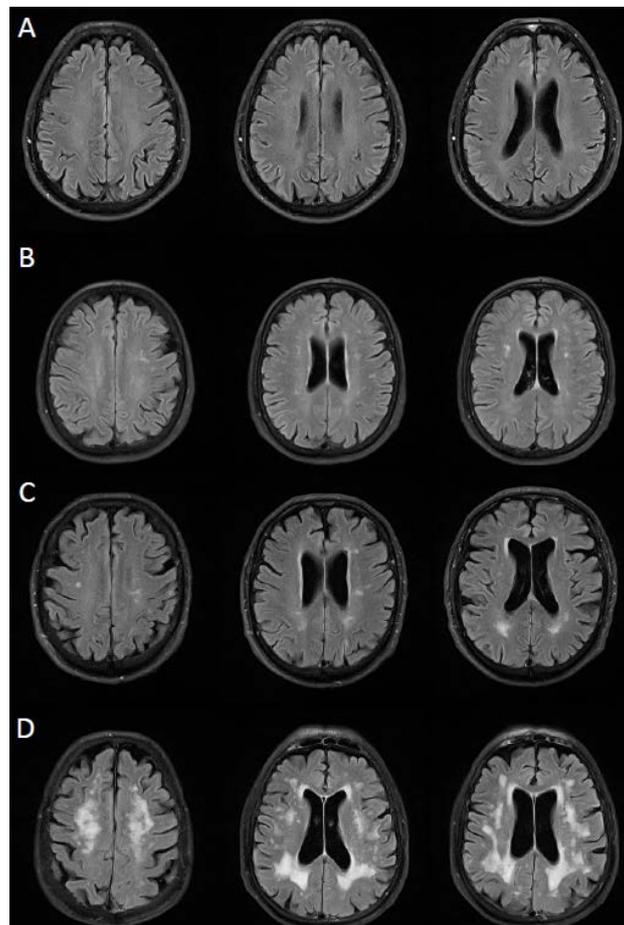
A fluid-attenuated inversion recovery (FLAIR) magnetic resonance imaging (MRI) sequence of a 66-year-old male patient (A) with an overall Fazekas and Wahlund score of 0. A 70-year-old female patient (B) with a Fazekas score of 1 and Wahlund score of 4. An 82-year-old male patient (C) with a Fazekas score of 2 and Wahlund score of 9. A 65-year-old male patient (D) with a Fazekas score of 3 and Wahlund score of 20.
